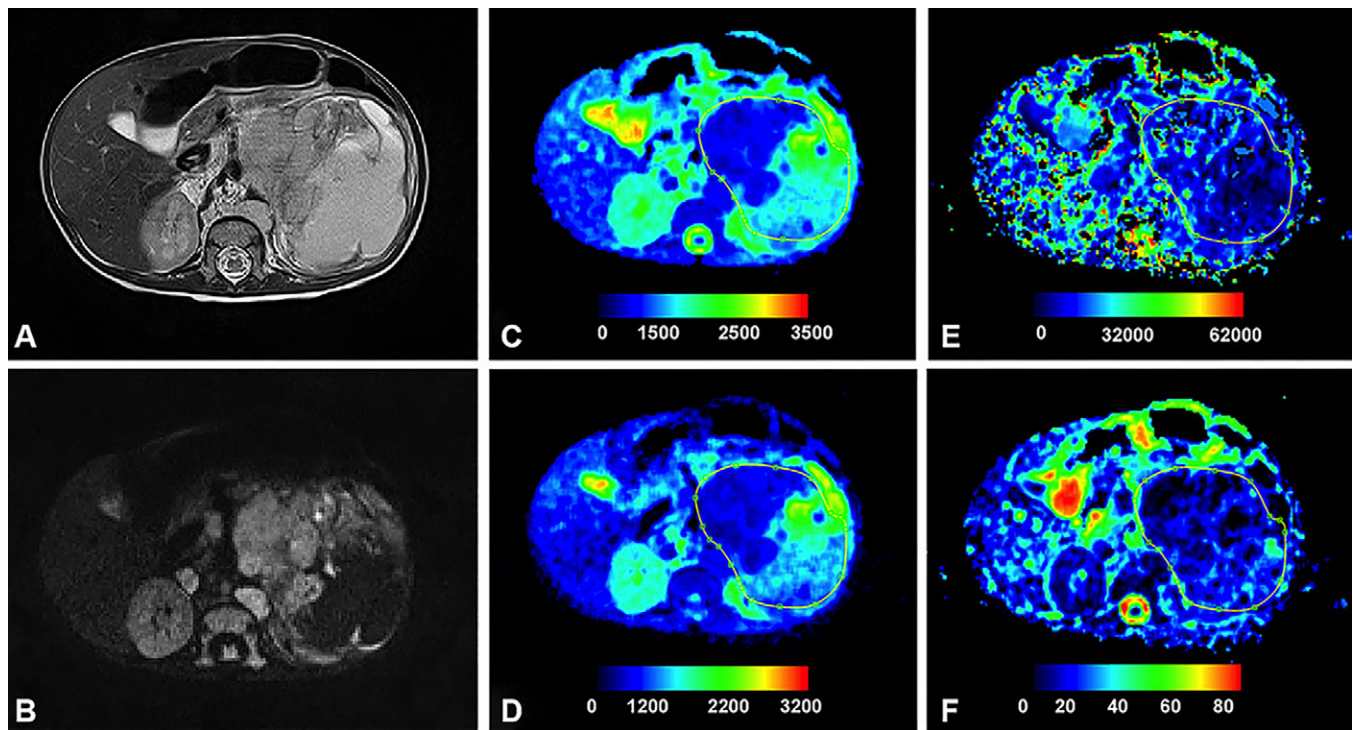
A case of grade IV neuroblastoma. (A, B) Axial T2-weighted and b value of 150 sec/mm² images, respectively. (C–F) Maps for the apparent diffusion coefficient, D , D^* , and f , respectively. The median values calculated for the apparent diffusion coefficient, D , D^* , and f from the entire tumor region of interest were 1.155×10^{-6} mm²/sec, 703×10^{-6} mm²/sec, 17762×10^{-6} mm²/sec, and 23%, respectively. (Adapted, under a CC BY 4.0 license, from reference 33.)
